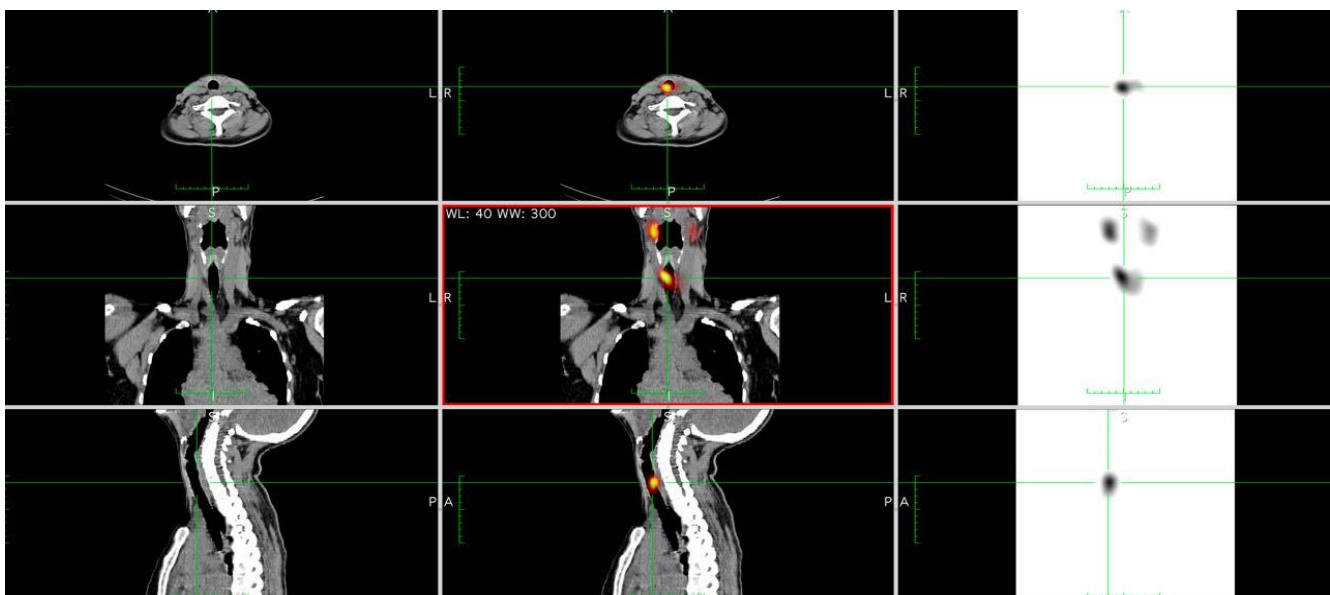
Following total thyroidectomy, thyroid scan with SPECT/CT images demonstrating radioactive isotope uptake at location of thyroid implant
